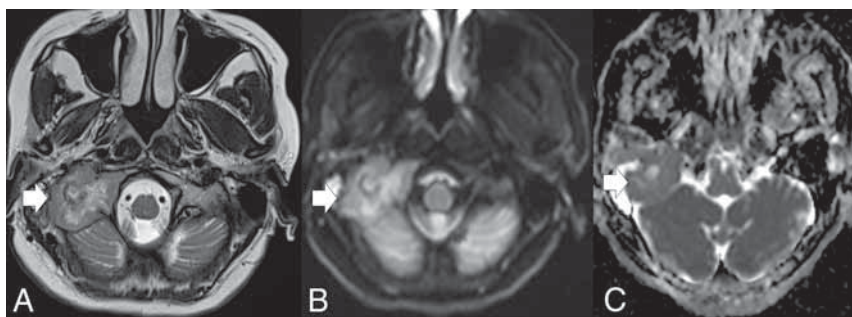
GCG of the right petrous bone. The lesion (*arrow*) is heterogeneous with peripheral, intermediate-signal-intensity soft tissue and central cystic area on (A) T2-weighted. DWI (B) and ADC map (C) of the lesion.
